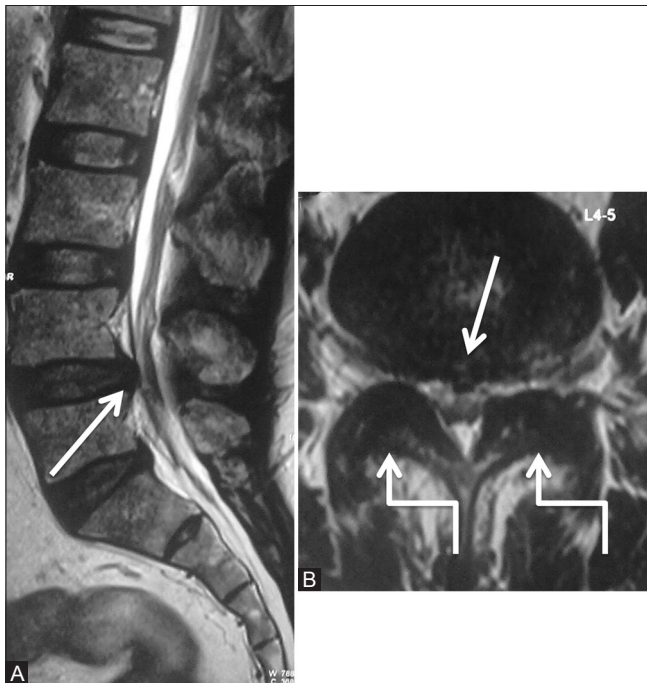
(A and B): Degenerative: Synovial cyst: Preoperative scan: Sagittal (A) and axial (B) T2-weighted images in a 59-year-old male patient with lower limb radiculopathy, showing diffuse disc bulge (arrow) at L4-5 level along with moderate degenerative facet arthropathy (elbow arrow), causing moderate to severe canal and bilateral lateral recess narrowing. Patient underwent decompressive laminectomy at the L4-5 level
